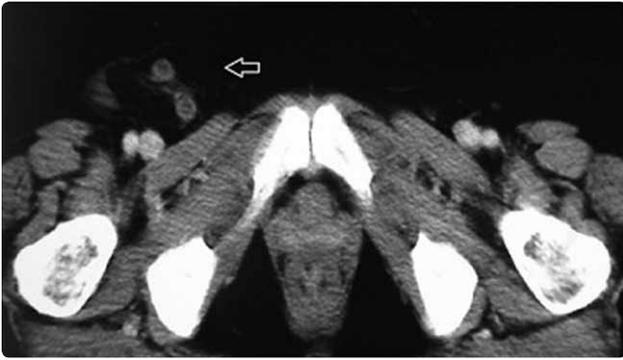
Inflamed appendix in the hernia sac is shown with arrow on computed tomography scan.
